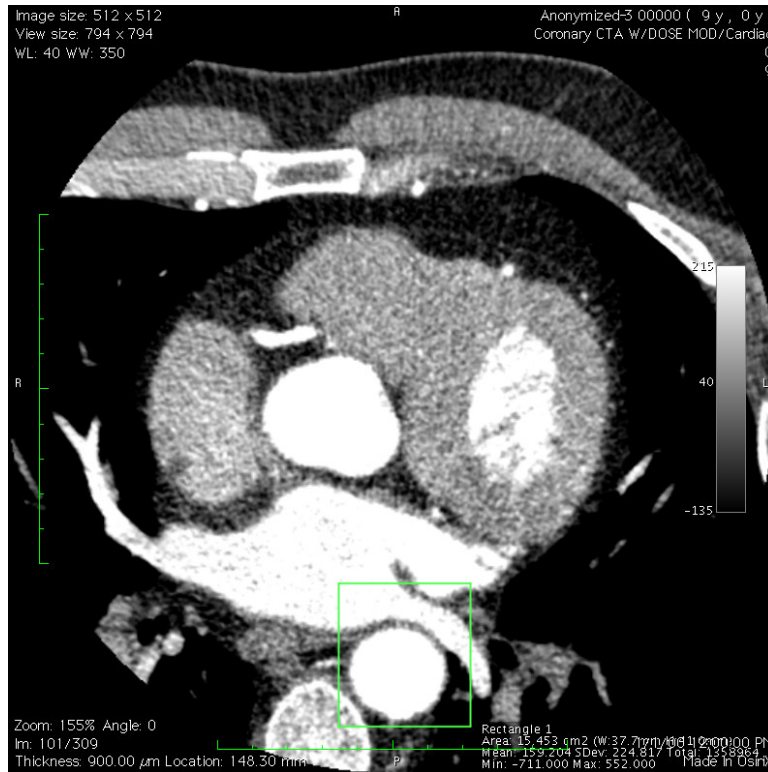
Full cardiac CT slice with a manually selected region of interest.
